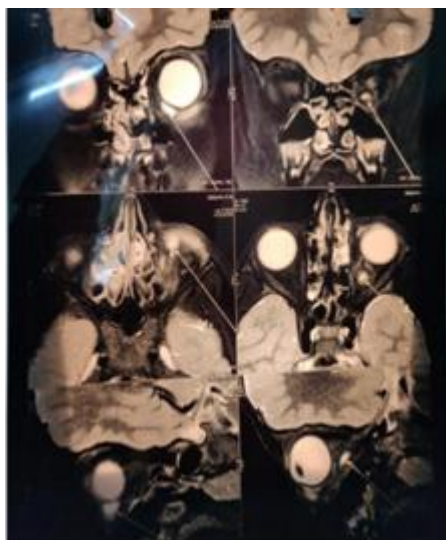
(b): MRI showing cysts in the left inferior rectus muscle.
